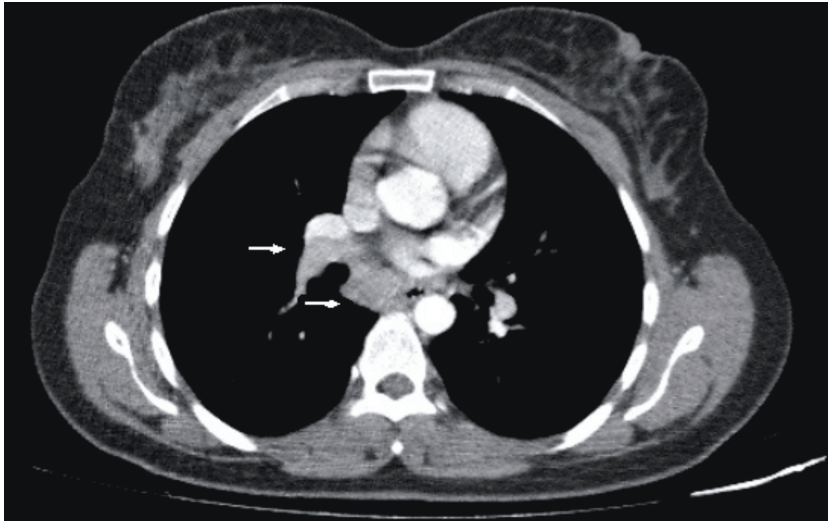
Thorax CT showing right hilar (11R) and subcarinal (7) lymph node of the patient, performed by EBUS-TBNA.
